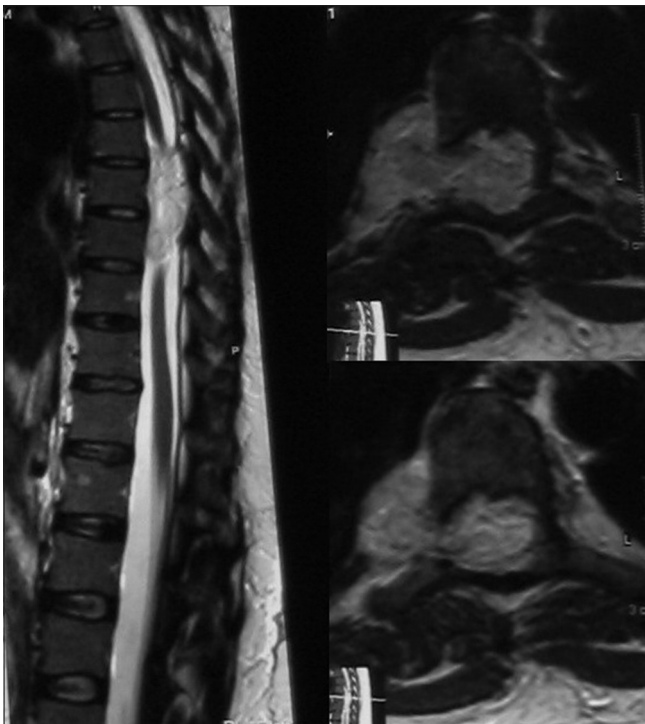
Sagittal T2-weighted image (left) and axial T1-weighted image after gadolinium administration (right), showing the D7–D9 extension of the mass and the spinal cord compression. At the D8 level, it is evident the invasion of the right peripleural space through the right conjugation canal.
